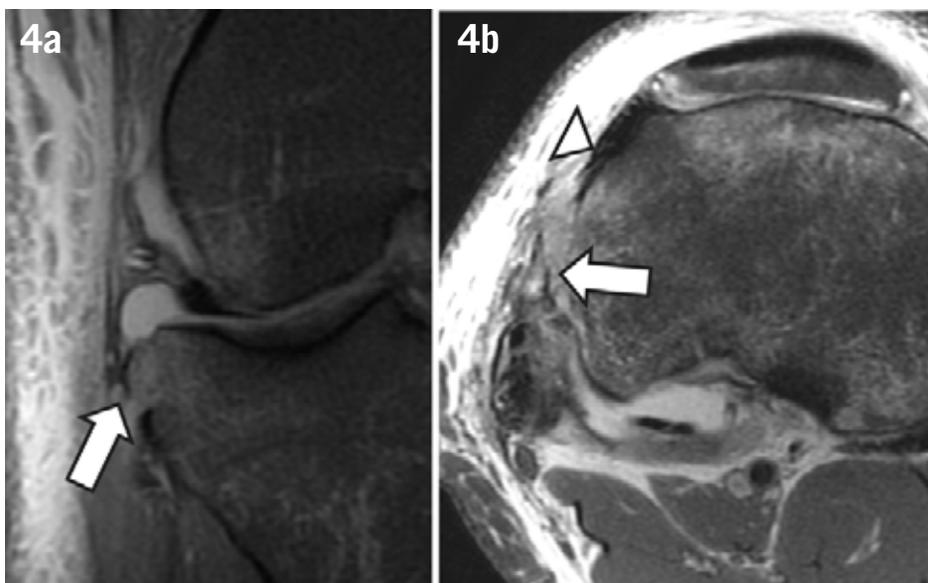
Magnetic resonance imaging of a patient with an ACL tear and a Segond Fracture. Coronal (a) and axial (b) T2 weighted images with fat saturation depicting a small cortical avulsion (arrows) in the lateral side of the tibia, posterior to the Gerdy's tubercle (arrowhead in b), consistent with a Segond fracture, an avulsion of the anterolateral ligament.
